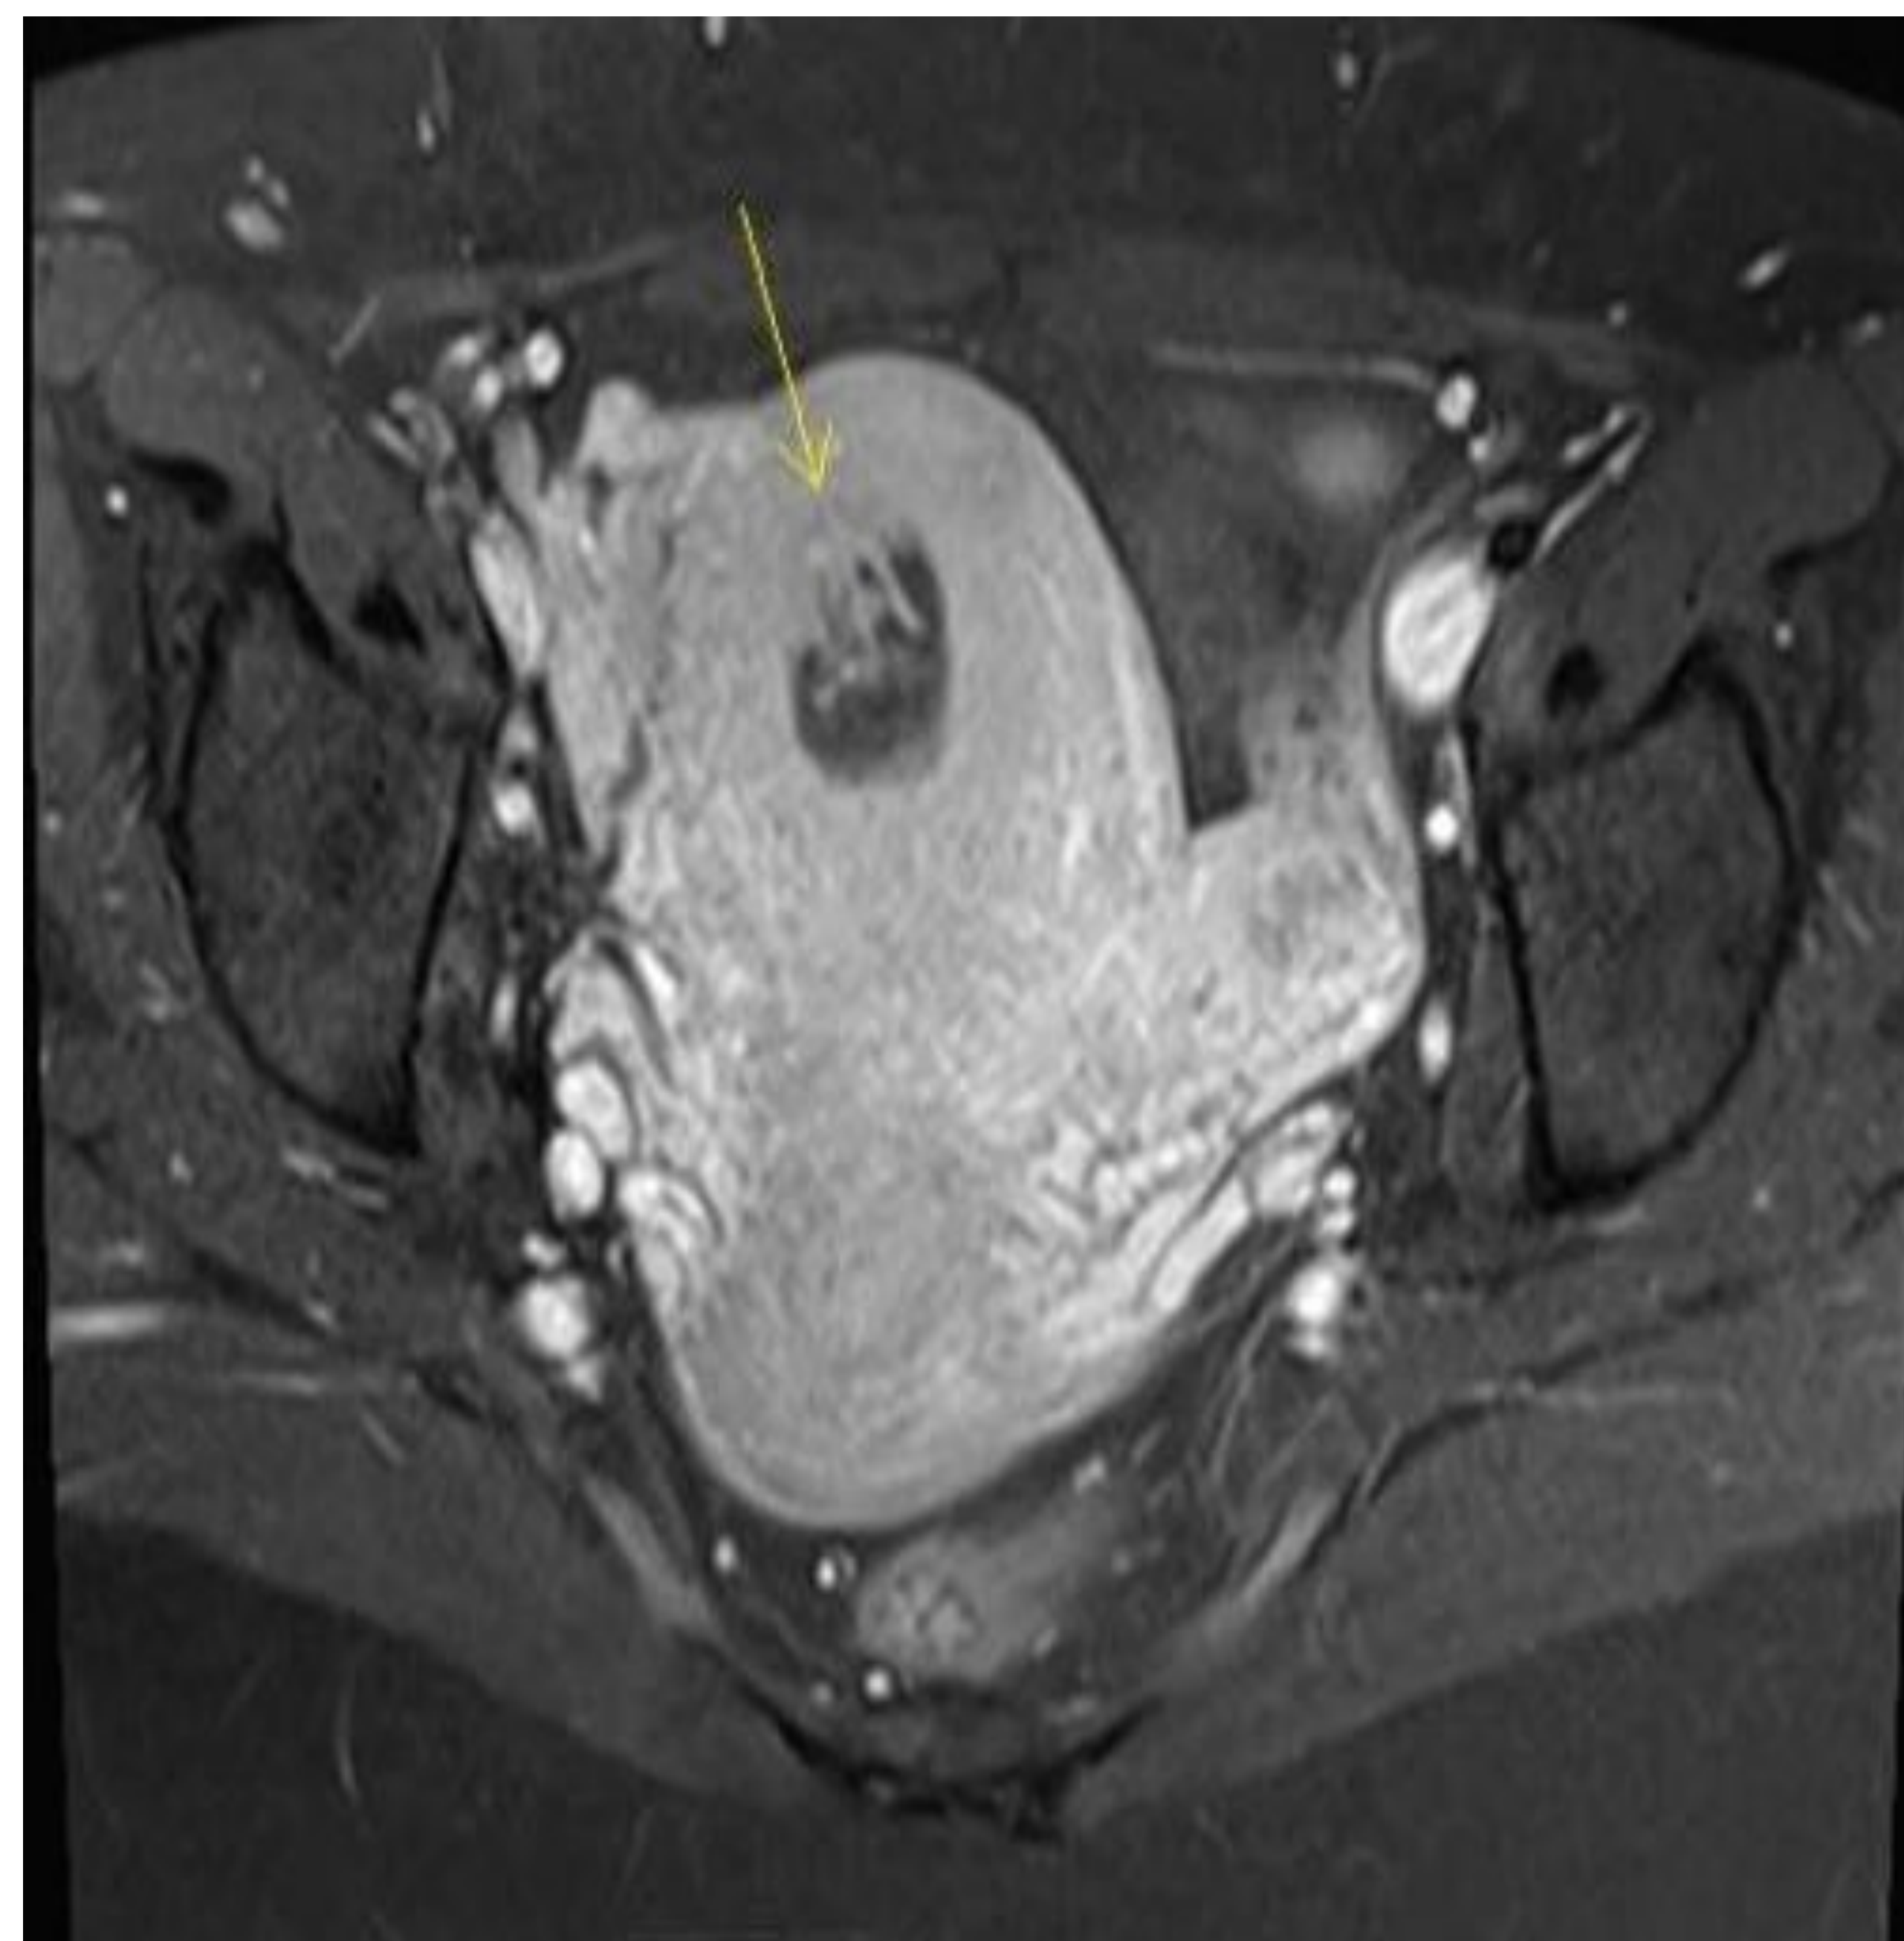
MRI Pelvis: Uterus 10.8 x 5.5 x 6.4cm, reveals small focus of retained products of conception without evidence of uterine invasion
